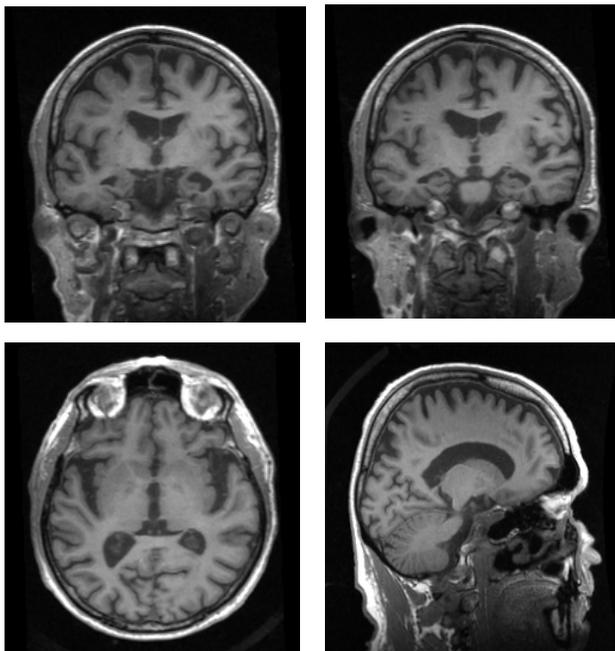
MRI of E.C.'s brain
